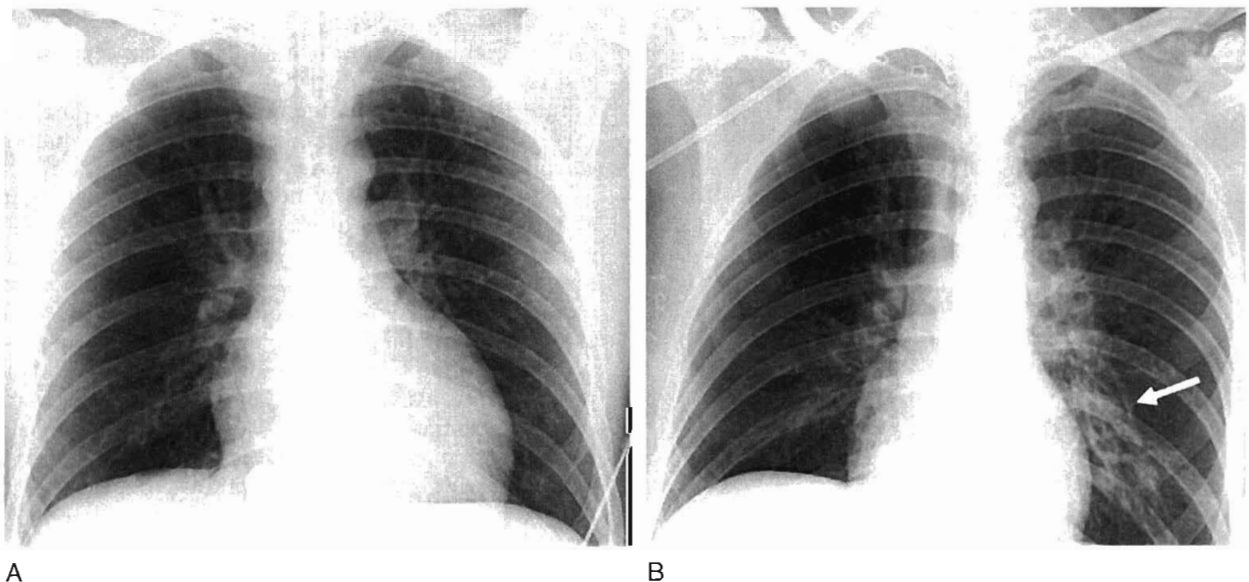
A 49-year-old man presented with seizure and witnessed aspiration. A, Initial anteroposterior chest radiograph is normal. B, Twenty-four hours later, patchy left lower lobe opacity (*arrow*) has developed, consistent with aspiration pneumonia. Note the increased opacity behind the heart.
